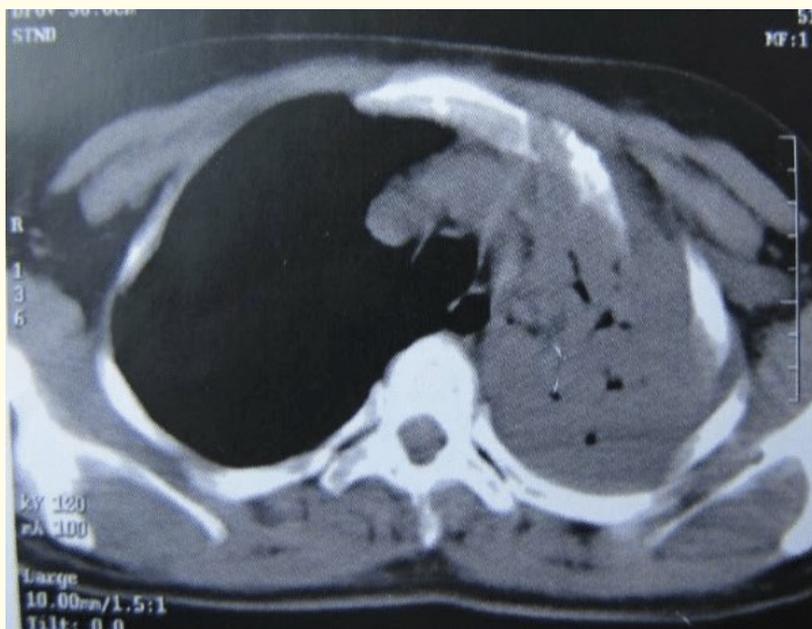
Pre-operative CT scan image shows left pulmonary upper lobe pneumonia associated with a complete lobar atelectasis.
